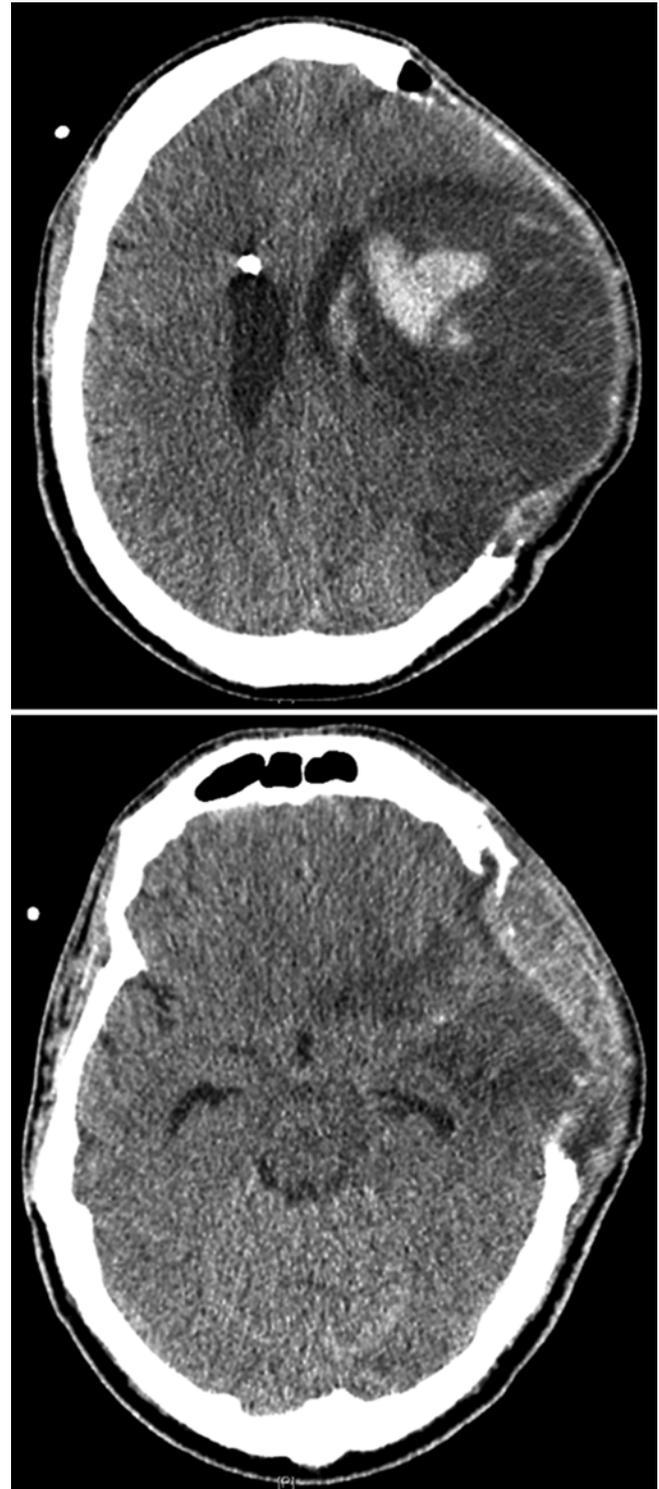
Axial computed tomography scans without contrast agent showing the dimension of a large frontotemporoparietal flap (large flap)
